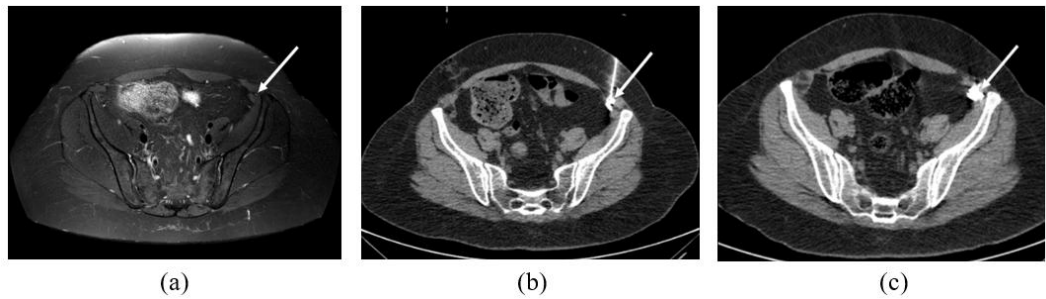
MRN and CT Images Depicting Continuous Radiofrequency Ablation of the Left Ilioinguinal Nerve. (a) Axial T2 DIXON water-only 3T-MRN image demonstrates a high signal within the left ilioinguinal nerve targeted for ablation (white arrow); (b) Axial CT shows needle placement within the perineural space of the left ilioinguinal nerve adjacent to the anterior superior iliac spine (white arrow); (c) Post-ablation image reveals expected changes in the perineural space without immediate complications (white arrow).
